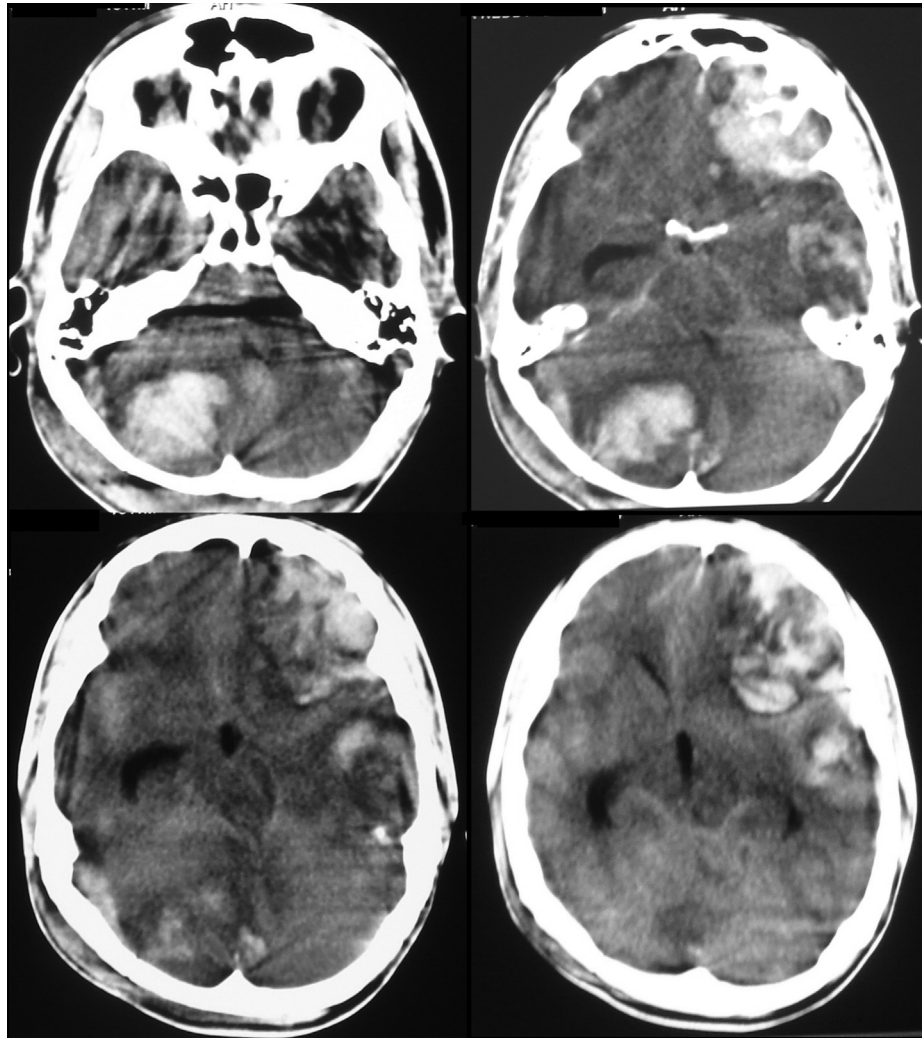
CT scan 18 h after post injury showing extensive contusion involving right cerebellar hemisphere, left frontal and temporal lobe with significant mass effect and midline shift including distortion of 4th ventricle and brain stem (because of cerebellar contusion).
